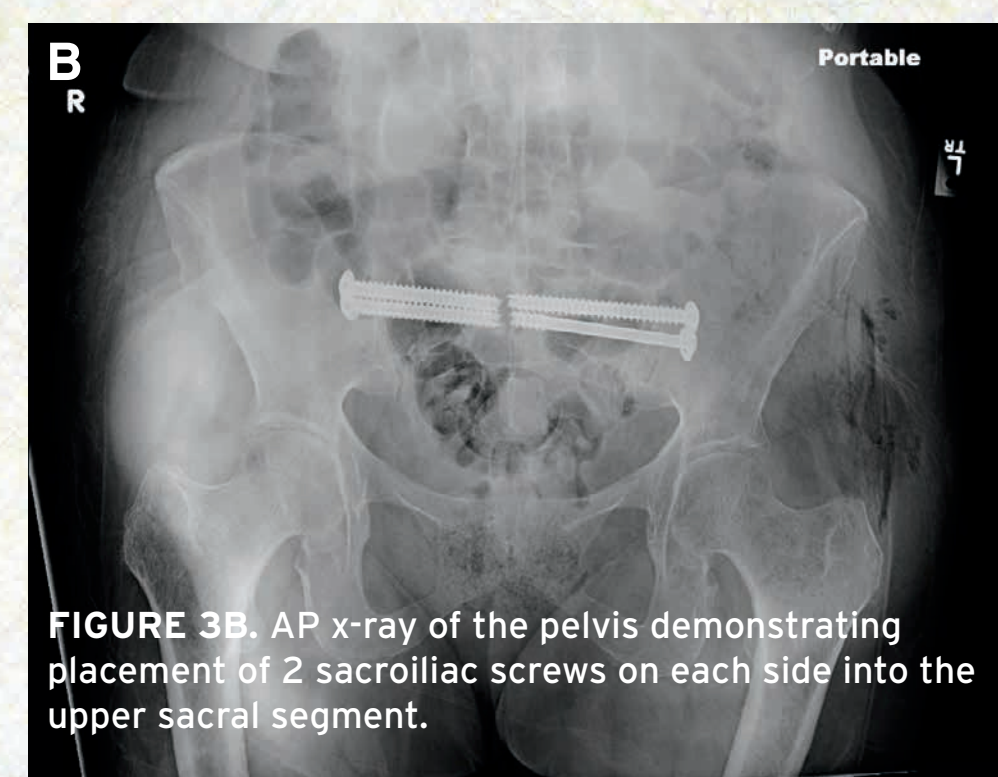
AP x-ray of the pelvis demonstrating placement of 2 sacroiliac screws on each side into the upper sacral segment.
